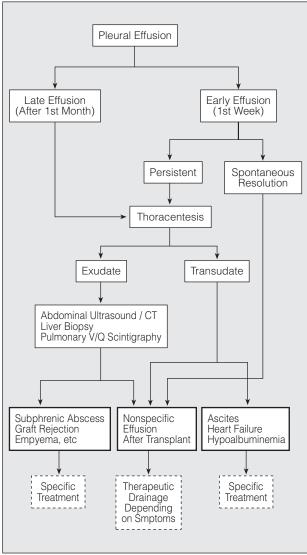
Algorithm for the management of pleural effusion after liver transplantation CT indicates computed tomography; V/Q ventilation/perfusion.
